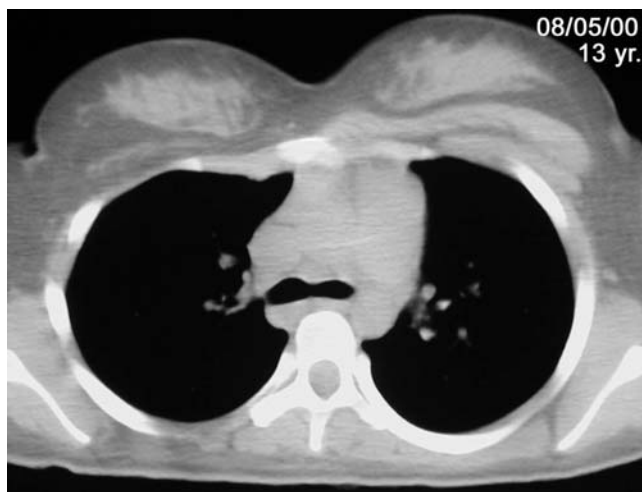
Poland syndrome in a 13-year-old girl with asymmetrical thorax. Axial CT image shows hypoplasia of the right pectoral muscle. The chest radiograph showed a hyperlucent right hemithorax (not shown)
